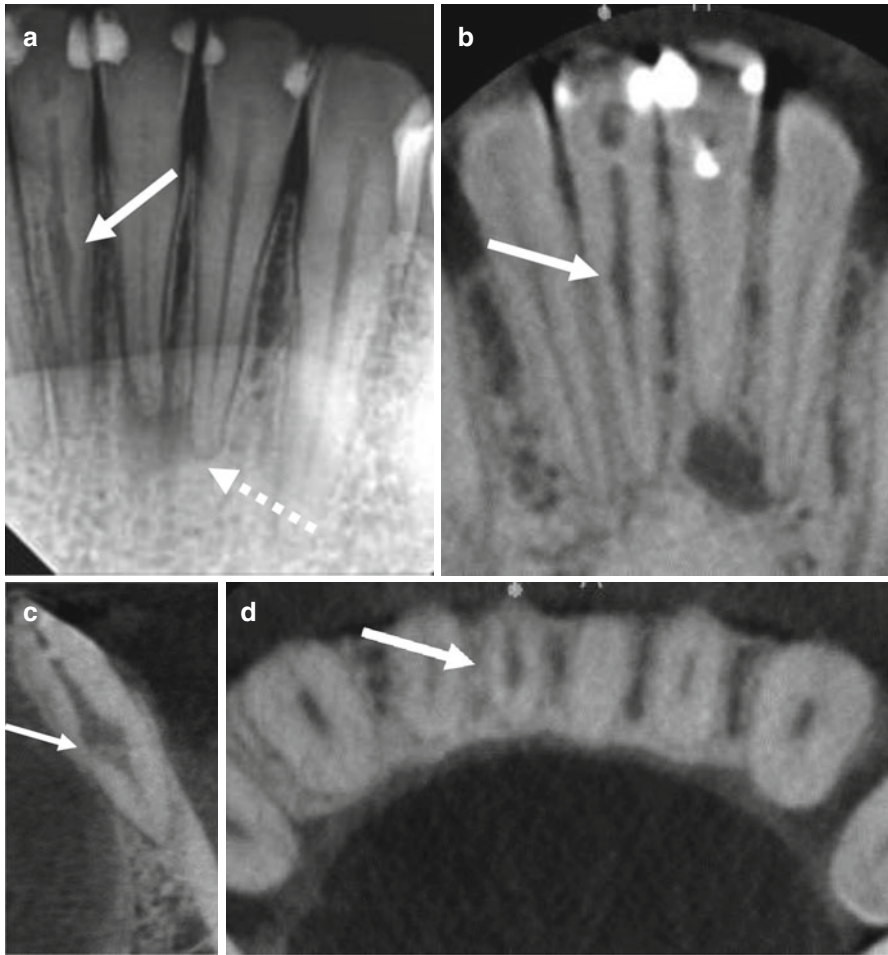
Clinically detectible internal root resorption is considered a rare occurrence. A 33-year-old female presented for evaluation and possible treatment with a history of trauma to the mandibular anterior region. (a) Periapical radiograph shows a centrally located, well-defined, irregular area of low density (*arrow*) in the mandibular right central incisor; features consistent with internal resorption. The mandibular left central incisor shows a well-defined, uniformly radiolucent area of low density centered over a point at the apex; features consistent with pulp necrosis and calcification of the canal. CBCT images of the (b) coronal reformation (c) cross-sectional reformation, and (d) axial reformation demonstrate the same low-density area (*arrows*) of the mandibular right central incisor with greater dentinal penetration in the faciolingual dimension. Note the severe calcification of the mandibular left central incisor. Orthograde endodontic treatment was recommended for both teeth. The CBCT scan provided useful guidance to localize the calcified canal
